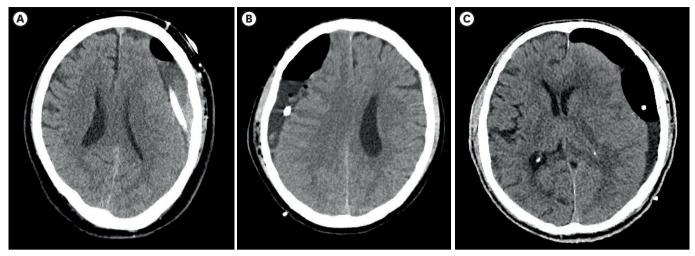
CT imaging of postoperative pneumocephalus categories. (A) No or mild, (B) Moderate, and (C) Severe. CT: computed tomography.
